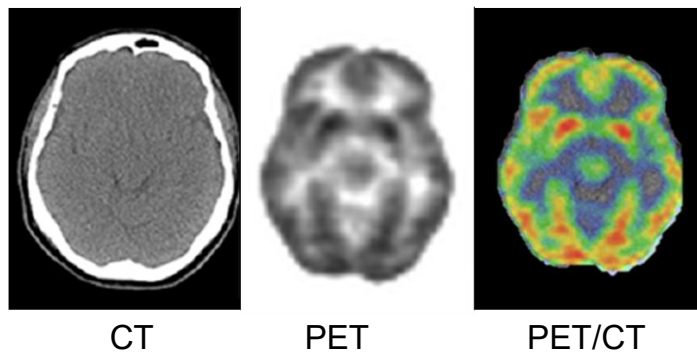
Clinical brain CT, PET, and fused PET/CT images which are adapted from [92].
